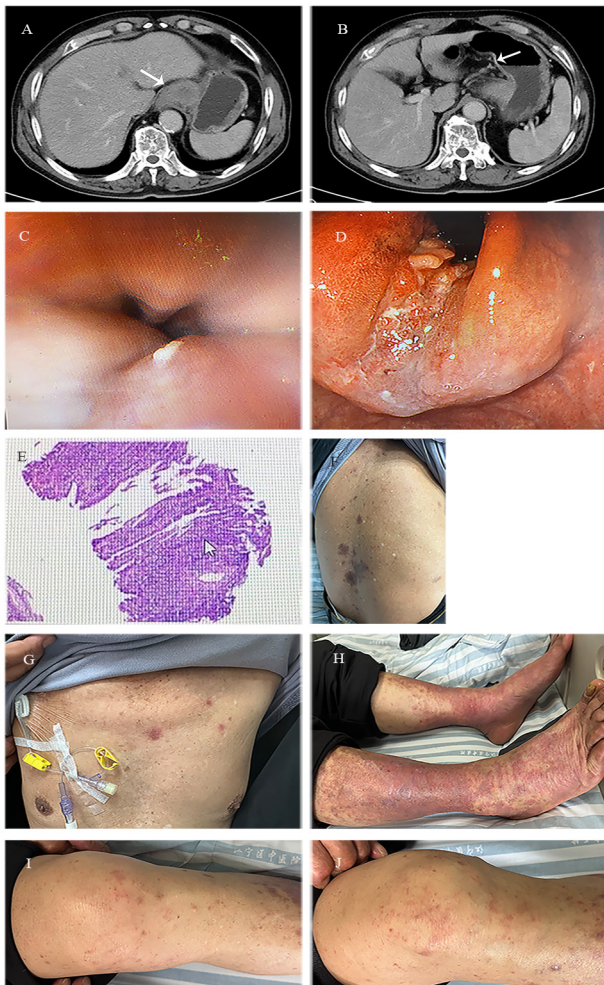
Radiological, endoscopic, pathological findings of gastric cardia adenocarcinoma and patient's skin before and after therapy. (A) Computed tomography scan revealed a mass of soft tissue in the fundus of the stomach, with uneven and moderate enhancement, with more pronounced enhancement in the edges, and an irregular serosal surface. (B) Multiple mildly enhanced and slightly enlarged lymph nodes were detected around the fundus of the stomach. (C) Gastroscopy revealed cardia stenosis, thus making it difficult for the gastroscope to pass through. (D) The gastroscopic findings indicated that the cardia extended to the lower esophagus and the fundus of the stomach, with a large irregular bulge, surface erosion, white coating and unclear boundaries. The biopsy was brittle and easily bleeding. (E) The pathological diagnosis was cardiac adenocarcinoma. (F-J) Prior therapy, the patient developed a widespread rash all over the body.
